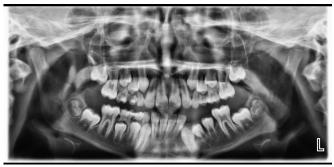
Panoramic radiograph of the case taken at the 4 months after decompression
